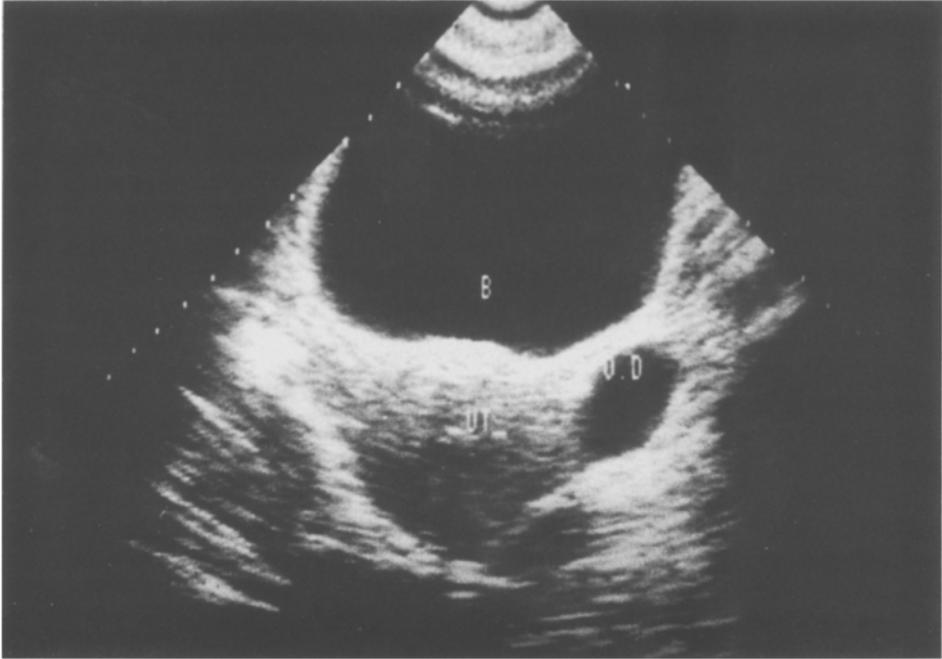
A typical ultrasound representation of a preovulatory follicle, which later ruptured. The woman had used a LNG-IUD for more than seven years. This picture was taken on day 15 of the cycle when LH level was 27.0 IU/L
